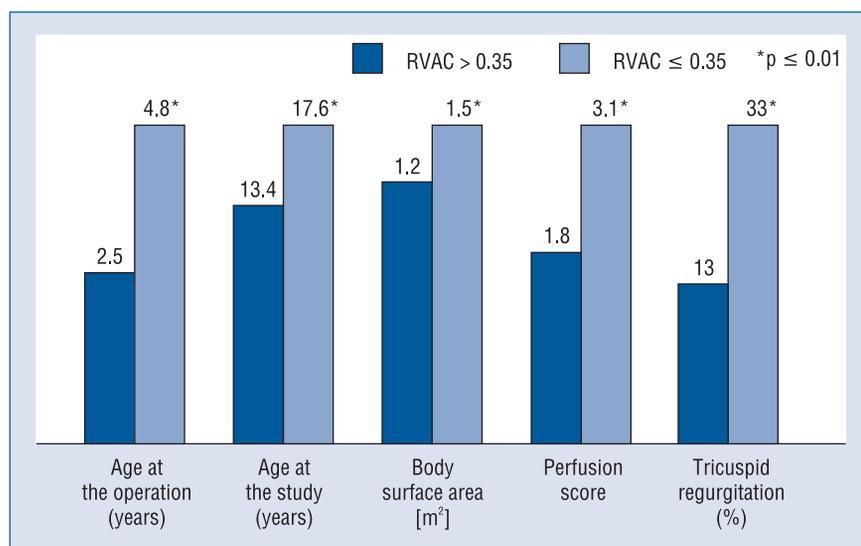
The comparison of selected demographic, echocardiographic and perfusion variables in patients with impaired versus preserved right ventricular function [right ventricular area change (RVAC) ≤ 0.35 vs. > 0.35].
